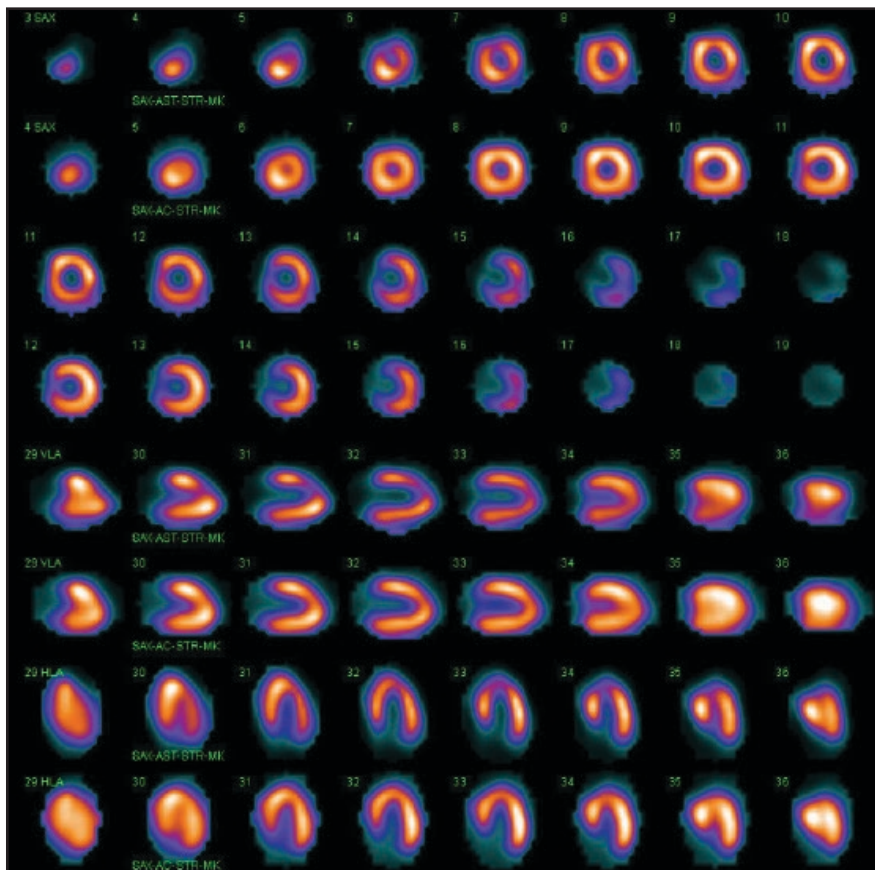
Nonattenuation-corrected (top row) and attenuation-corrected (bottom row) images from an MPI SPECT CT showing a small mild-to-moderate severity distal anteroseptal defect that resolves with attenuation correction and is attributable to breast attenuation.
